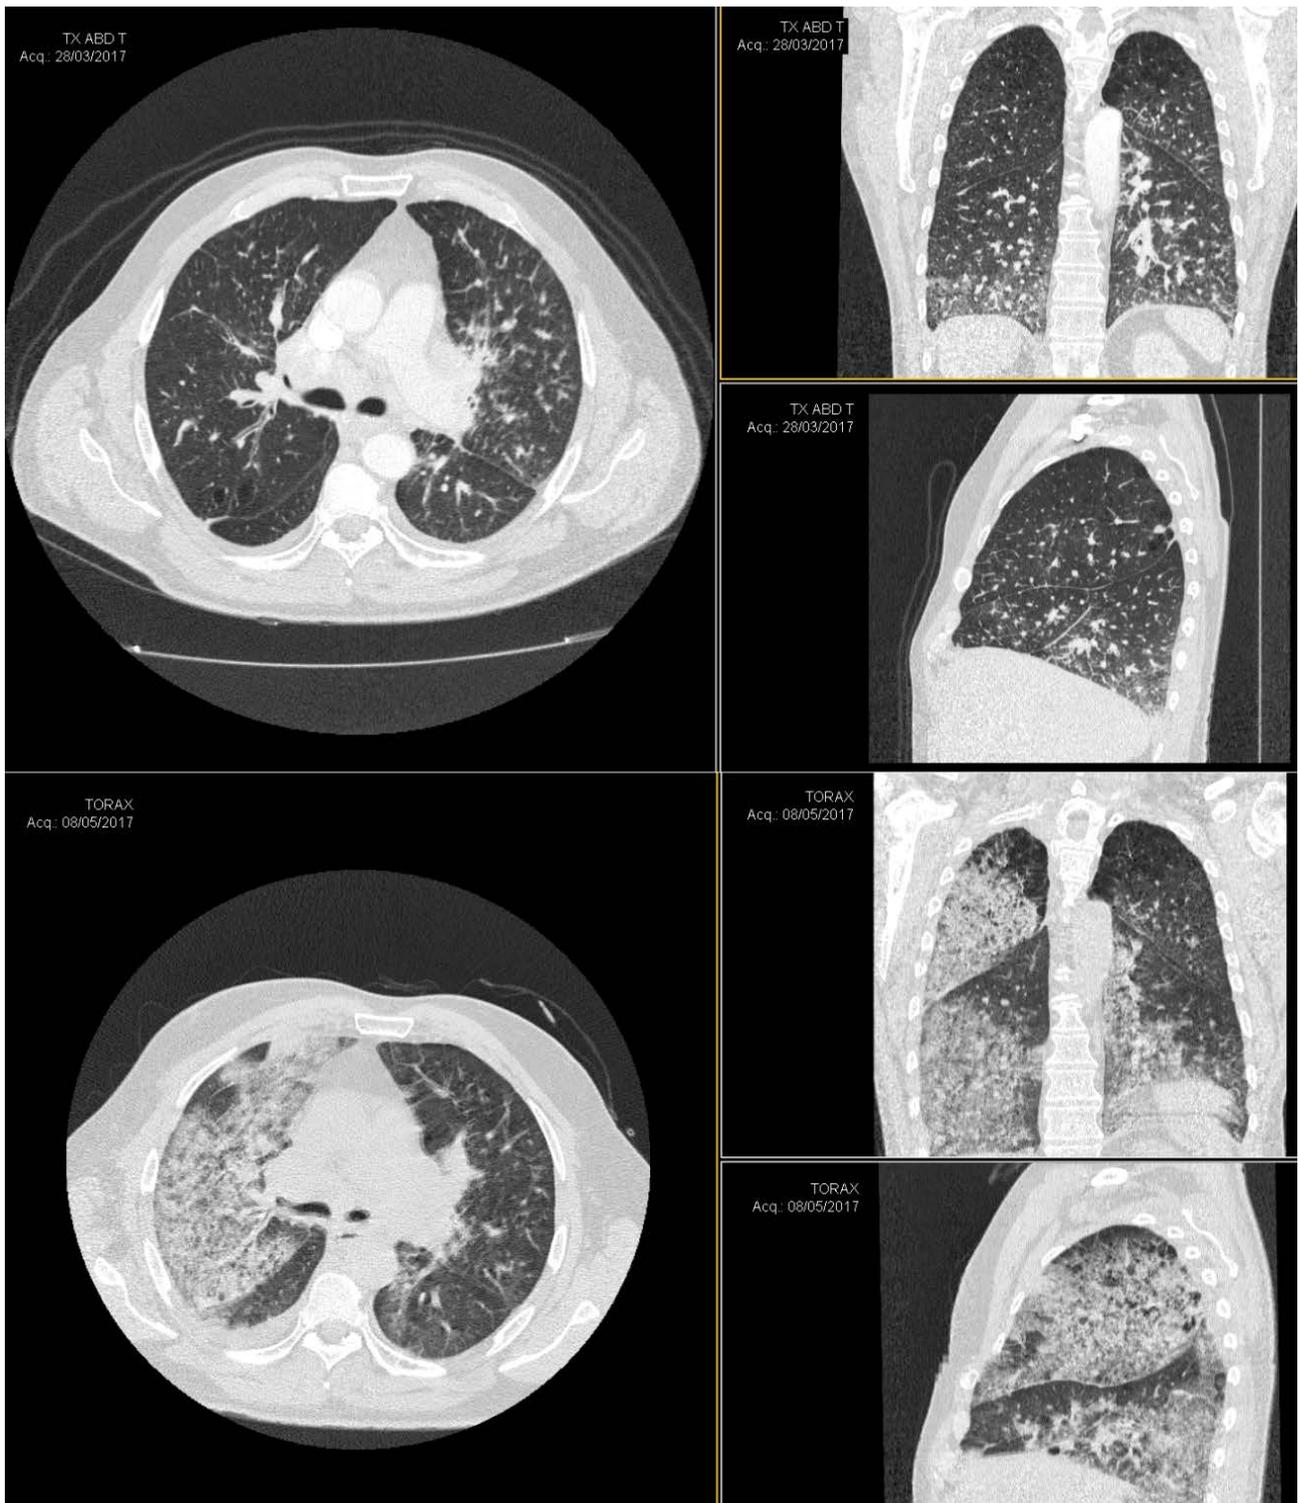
CT scan-Lung Window. Axial, coronal and sagittal views of March 28 (upper photos) and May 8 (lower photos)
